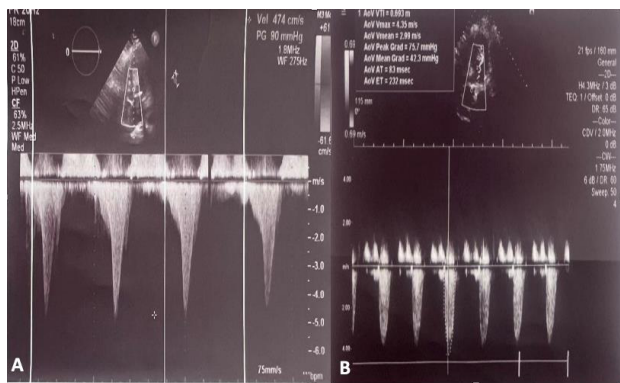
2-Dimensional Transthoracic Echocardiogram showing gradients across (A) Left Ventricular Outflow Tract and (B) Aortic valve
